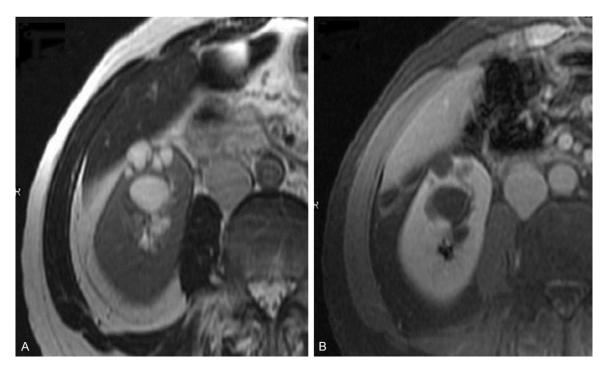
Magnetic resonance imaging. A. On a T2-weighted image, a renal mass with a maximum diameter of 3 cm can be observed, with multiple cysts present inside. B. On a contrast-enhanced T1-weighted fat-suppressed image, septa between the cysts showing enhancement similar to the normal renal parenchyma.
